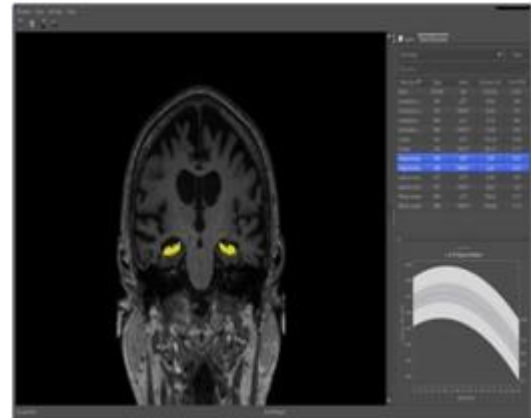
Example Of Structural Magnetic Resonance Imaging (MRI)
